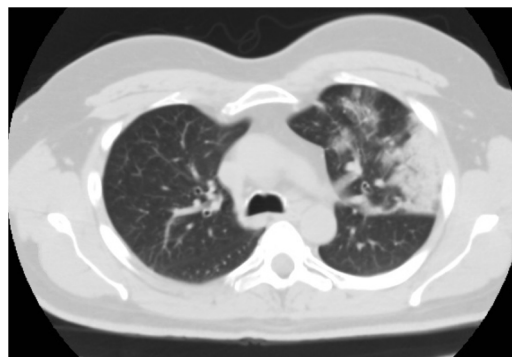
Chest CT scan revealing ground-glass parenchymal opacification in the upper lobe of the left lung.
